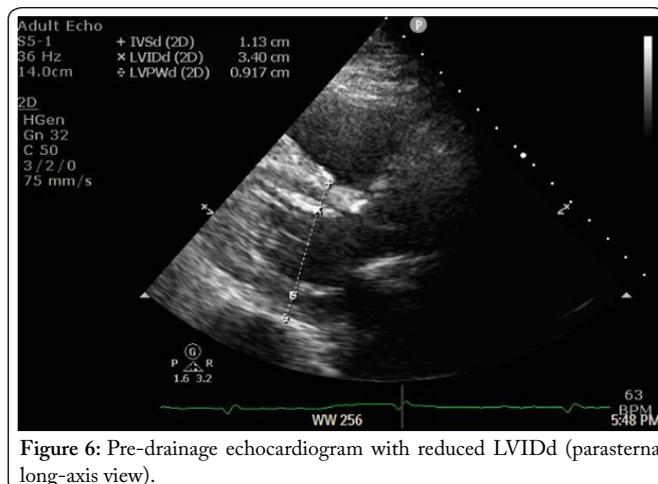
Pre-drainage echocardiogram with reduced LVIDd (parasternal long-axis view).
